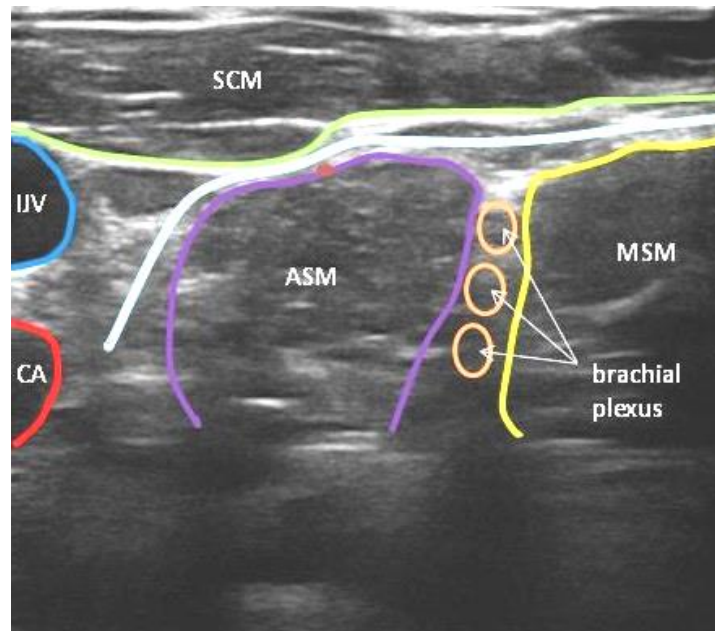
Ultrasound view of B-line
